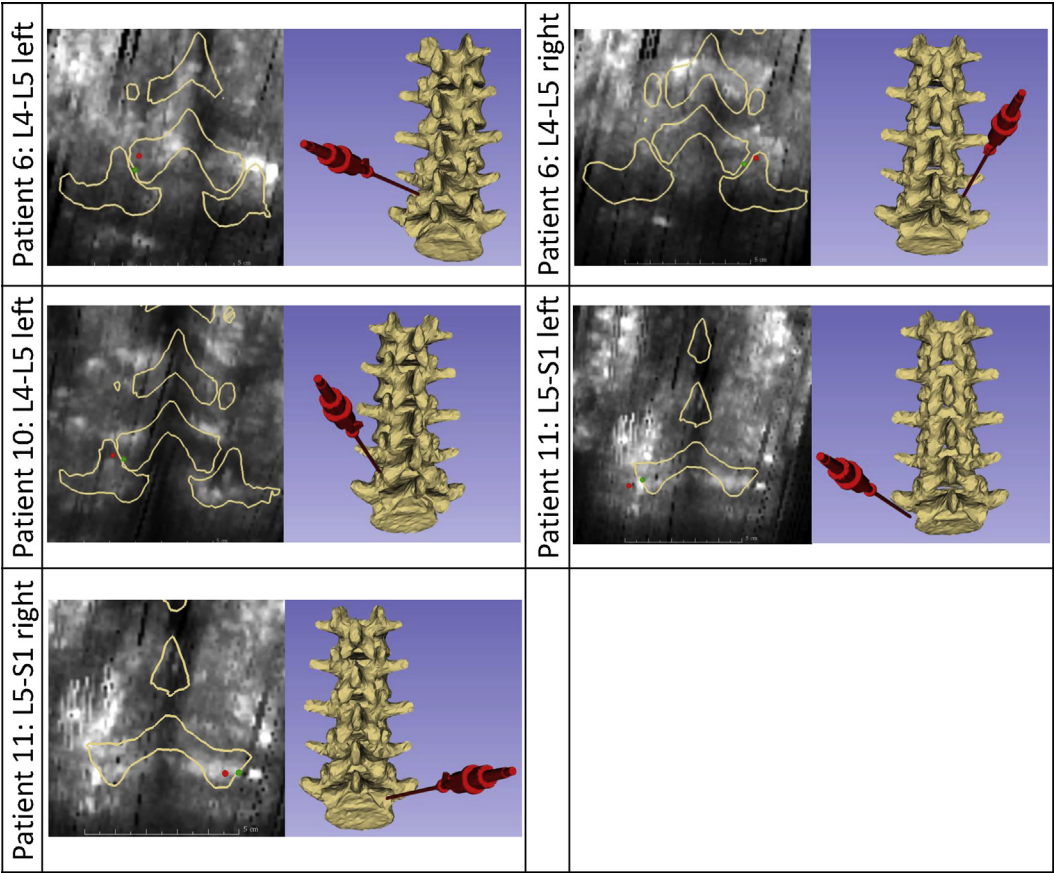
Results of facet joint injections for five patients. The 2-D view on the left for each patient depicts a coronal reformation of the ultrasound volume at the center of the facet joint (*green point*), the intersection of the needle vector with this coronal plane in *red*, and the registered model as *beige* overlay. On the right, the 3-D relation between the tracked needle and the registered model is visualized.
